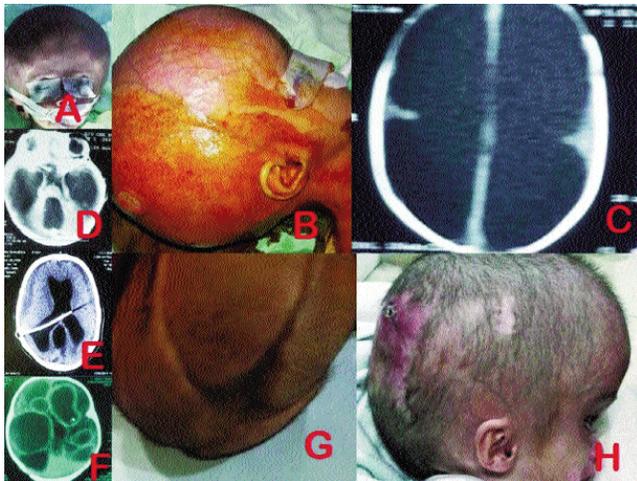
Scans and complications of Neglected Hydrocephalus. (A) Pre-op enlarged head with dilated veins and bulging fontanelle. (B) Pre-op pressure sore on bony prominence. (C) Computed tomography (CT) scan of head showing maximal hydrocephalus and thin cortical mantle. (D) CT Head showing gross cerebral atrophy with hydrocephalus. (E) Post-op CT Head showing shunt catheter in ventricles and bilateral chronic sub-dural haematomas (F) CT scan appearance of post-shunt infection ventriculitis. (G) Post-op sunken head and deformity. (H) Post-op cranial wound margin pressure sore.
